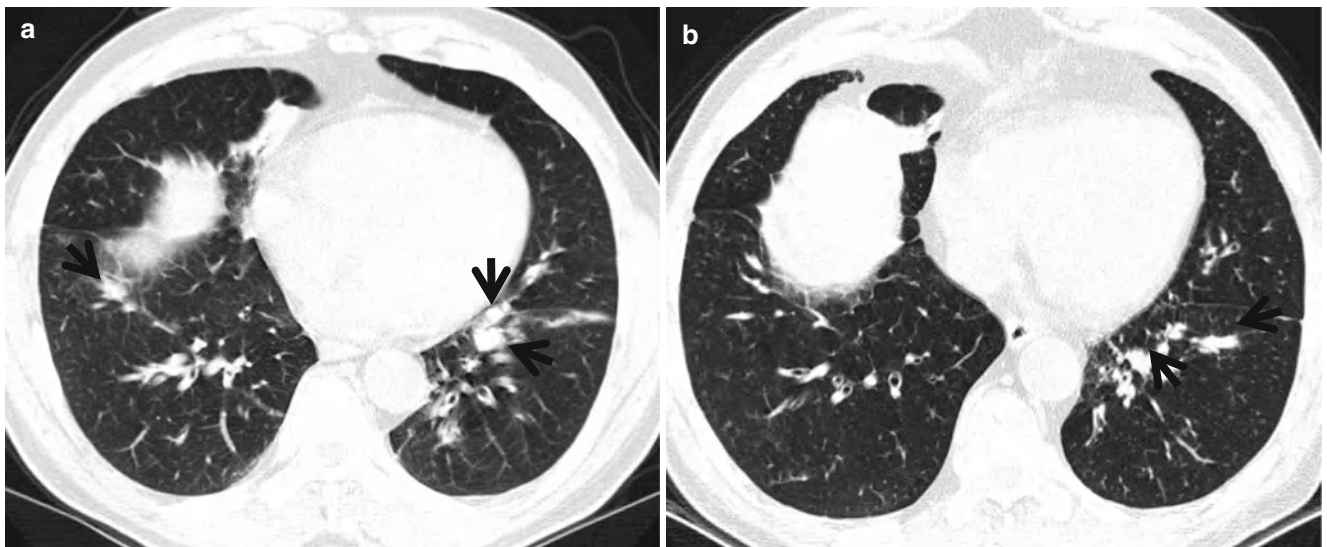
Allergic bronchopulmonary aspergillosis in a 64-year-old asthmatic man. (a, b) Lung window images of consecutive CT scans (2.5-mm section thickness) obtained at levels of liver dome show mucus
